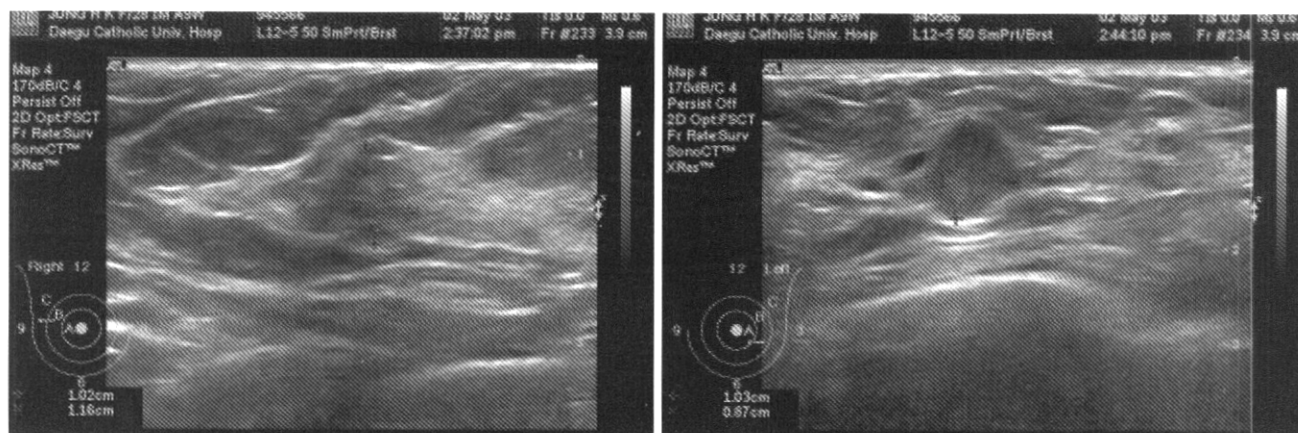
The ultrasonographic finding of breast shows multiple benign appearing hypoechoic masses in both breasts.
